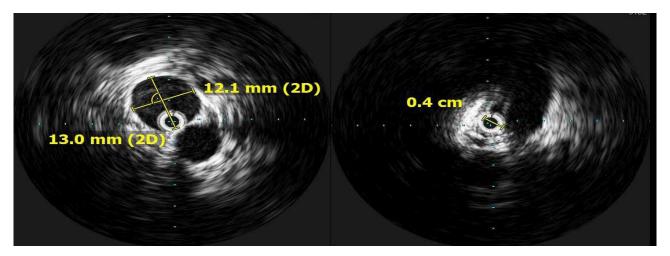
Intravascular ultrasound (IVUS) evaluation.
